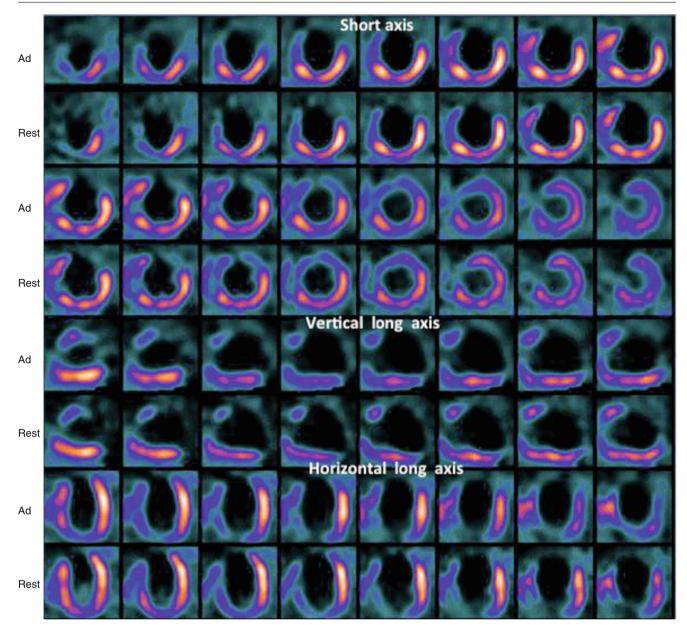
Adenosine stress (*Ad*) and rest 99mTc-sestamibi SPECT images of a 55-year-old man with long-standing history of CAD. He suffered from a large anterior wall myocardial infarction at the age of 36 years. He suffered from multiple myocardial infarction since then and has undergone multiple revascularization procedures. He developed progressively worsening heart failure despite maximum medical therapy. Ad and rest images show a markedly enlarged left ventricle with a
